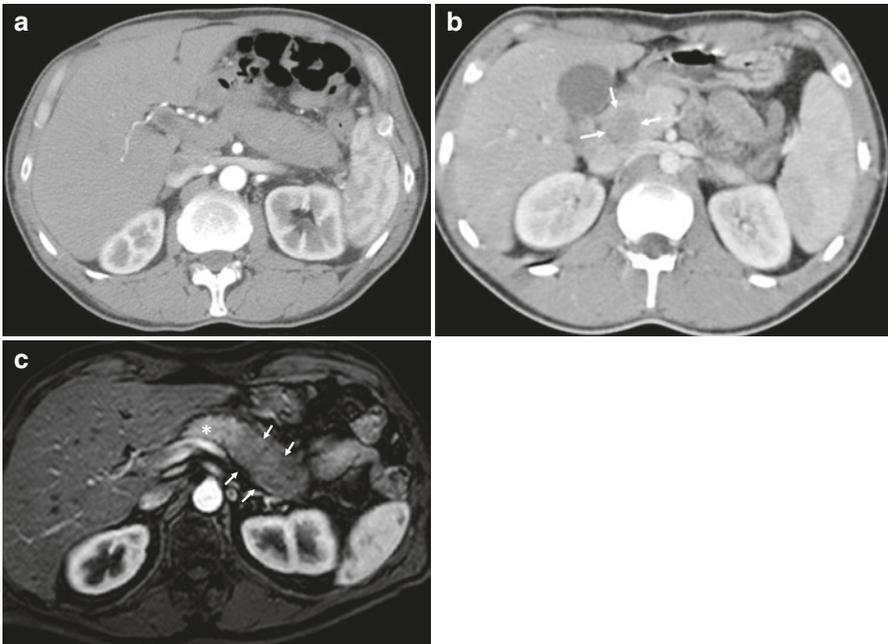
(a) Computed tomography (CT) appearance of diffuse AIP: the pancreatic parenchyma appears diffusely hypodense in the body-tail of the pancreas on arterial phase. (b) CT appearance of focal AIP: focal hypodensity in the head of the pancreas on pancreatic phase. (c) Magnetic resonance findings in focal AIP: the pancreatic parenchyma (*arrows*) appears hypointense at tail on pancreatic phase compared to body (*asterisk*) (“*black and white*” sign) at axial T2-weighted image
